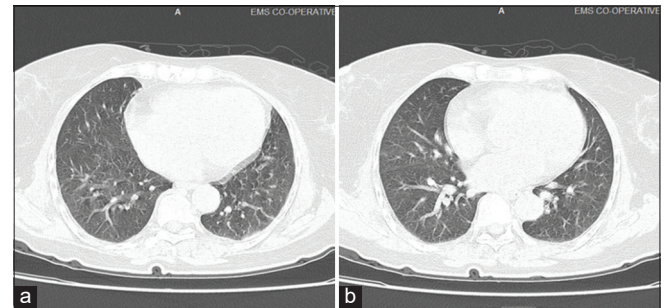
(a) Computerized tomographic (CT) thorax at follow-up after 6 weeks; (b) repeat CT showing clearance of nodules (Case 1)
